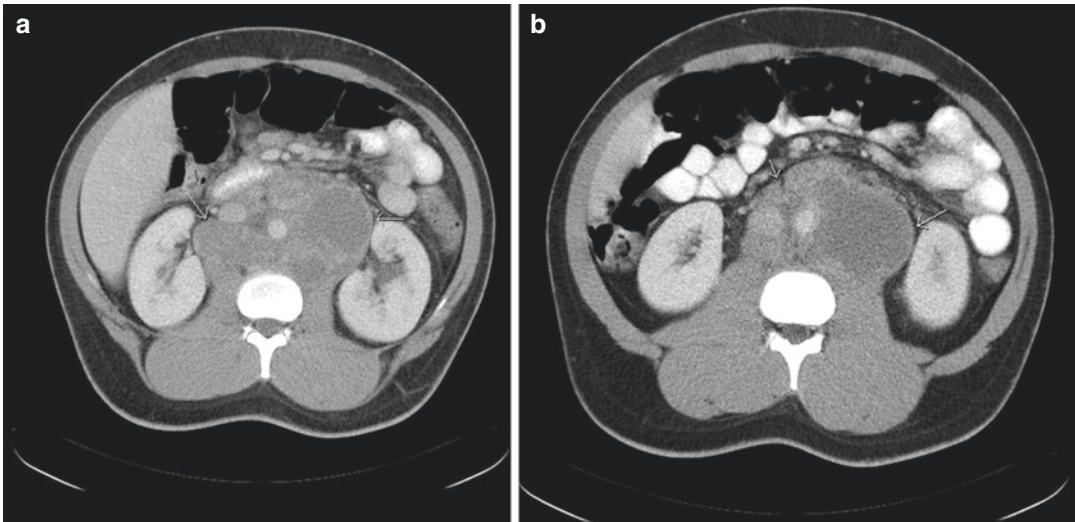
A 24-year-old man with metastatic nonseminomatous germ cell tumor. CT images (a, b) show a large heterogeneous retroperitoneal nodal mass (arrows)
